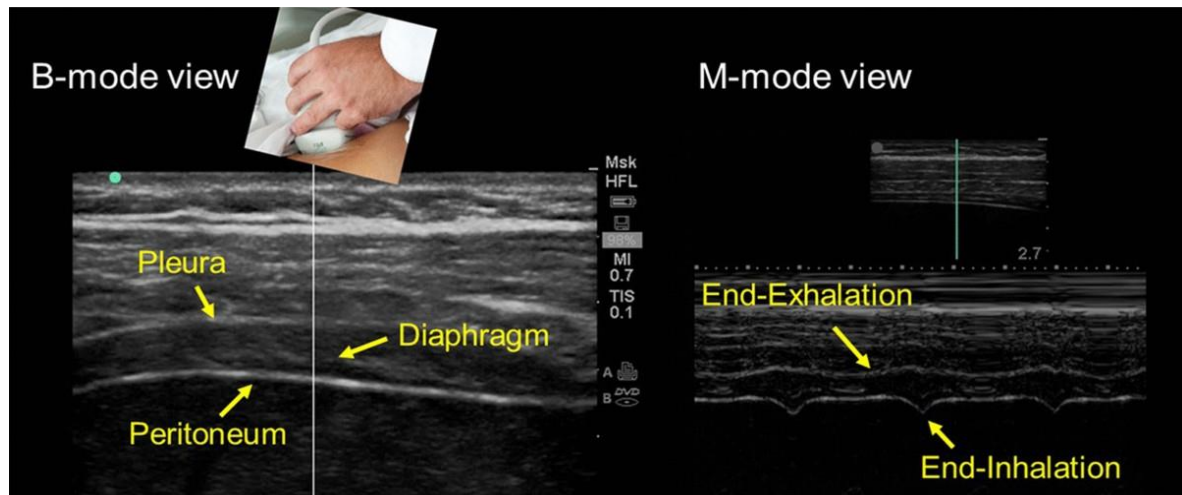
Diaphragmatic thickness by M-mode and B-mode ultrasound
